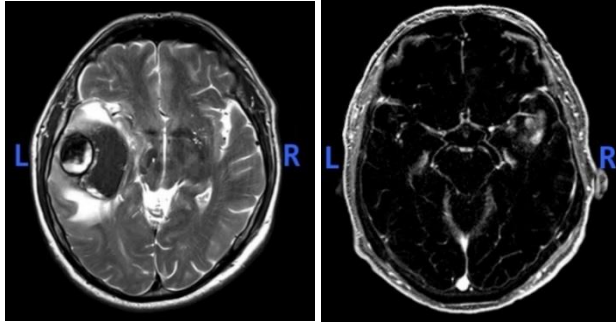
T2-weighted MRI of T-LH (left side) and T1-weighted MRI by T-RH (right side)
